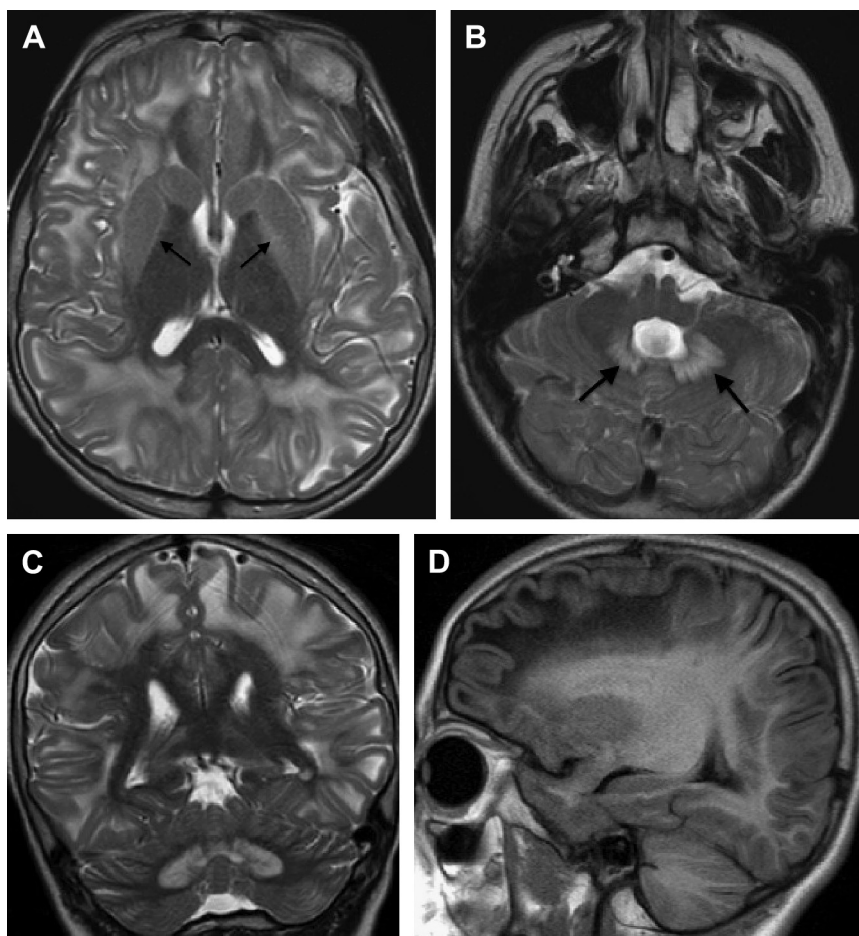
L-2-hydroxyglutaric aciduria in a 13-year-old boy. Axial T2-weighted (A, B), coronal T2-weighted (C) and sagittal T1-weighted (D) images demonstrate subcortical white matter signal abnormality, frontal predominant and sparing the central white matter. There is also peripheral corpus striatum and dentate nucleus signal increase (arrows).
